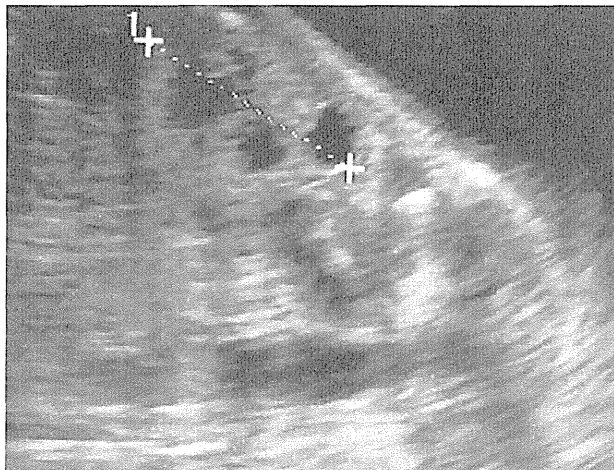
Ultrasound at 20 weeks of gestation revealed a left multicystic, dysplastic kidney in fetus A.
